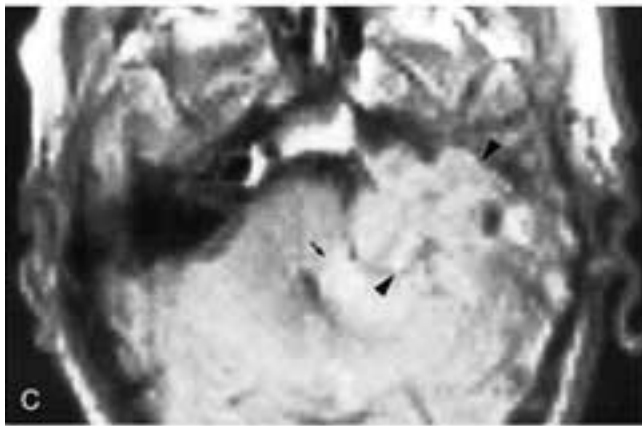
Malignant giant cell tumor. A and B, Axial CT. Ill-defined geographic borders suggest a moderately aggressive lesion. Destruction of the otic capsule is atypical of paraganglioma. C, Proton density image. The tumor is inhomogeneous on T2-weighted images but lacks the salt-and-pepper heterogeneity seen in medium-sized or large paragangliomas on T1-weighted images (tumor, *arrowheads*; compare with [Fig. 25-71](#)). There is adjacent edema (*arrow*). D, Selective carotid angiogram. As in most malignant tumors, tumor vascularity is much less than in a paraganglioma. (Compare with [Fig. 25-70](#).)
